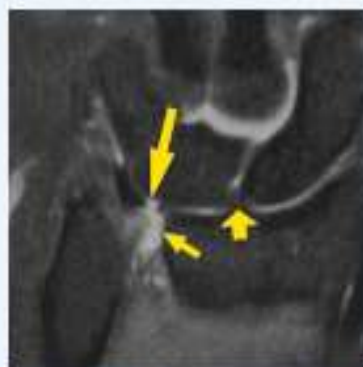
MRI showing central perforation of TFCC treatment.
